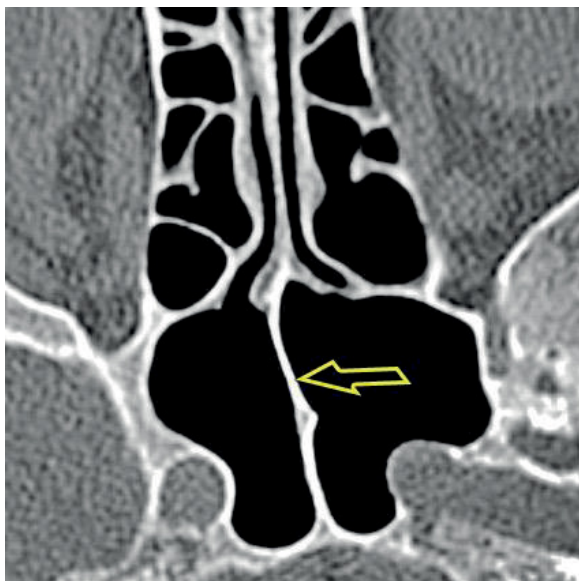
A CT scan of the paranasal sinuses, transverse plane. The medial course of the main septum.
